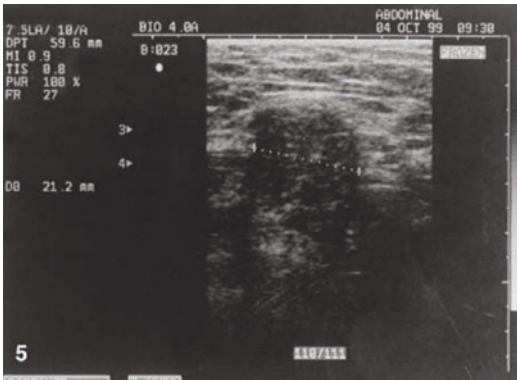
Calipers demonstrate margins of a direct hernia. With permission from Lilly MC, Arregui ME. Ultrasound of the inguinal floor for evaluation of hernias. *Surg Endosc.* 2002;16(4):659–662
